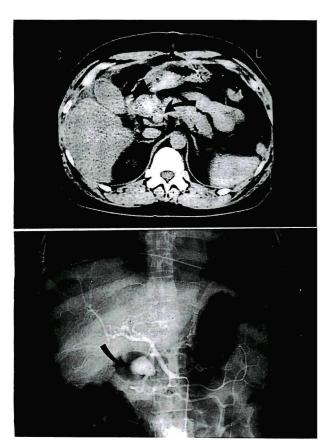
CT demonstrating a spherical mass (arrow) below the pylorus (upper). Celiac angiography revealing an oval aneurysm 3cm in diameter of the gastroduodenal artery (bottom).
